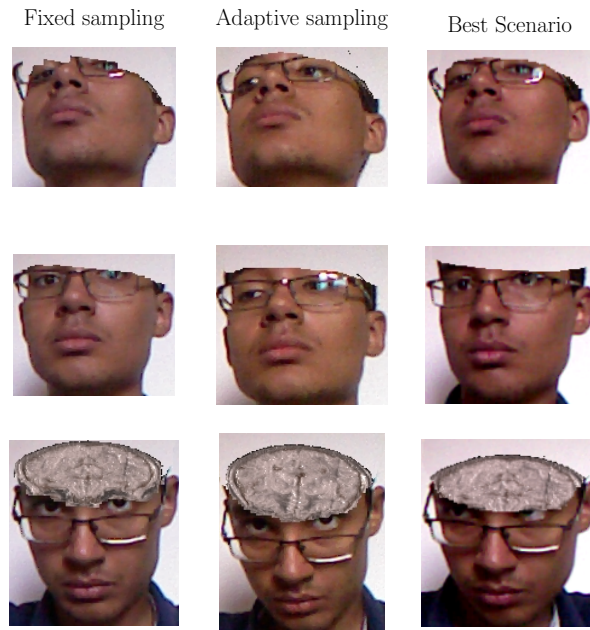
Different schemes for F+C visualization based on visible background on MRI Data.
